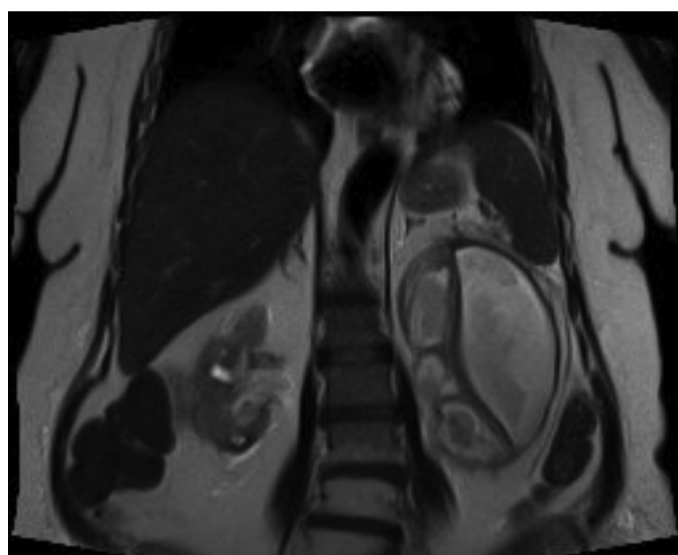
Left perirenal, subcapsular 10X8 cm hematoma and clot in the collecting system on magnetic resonance imaging
